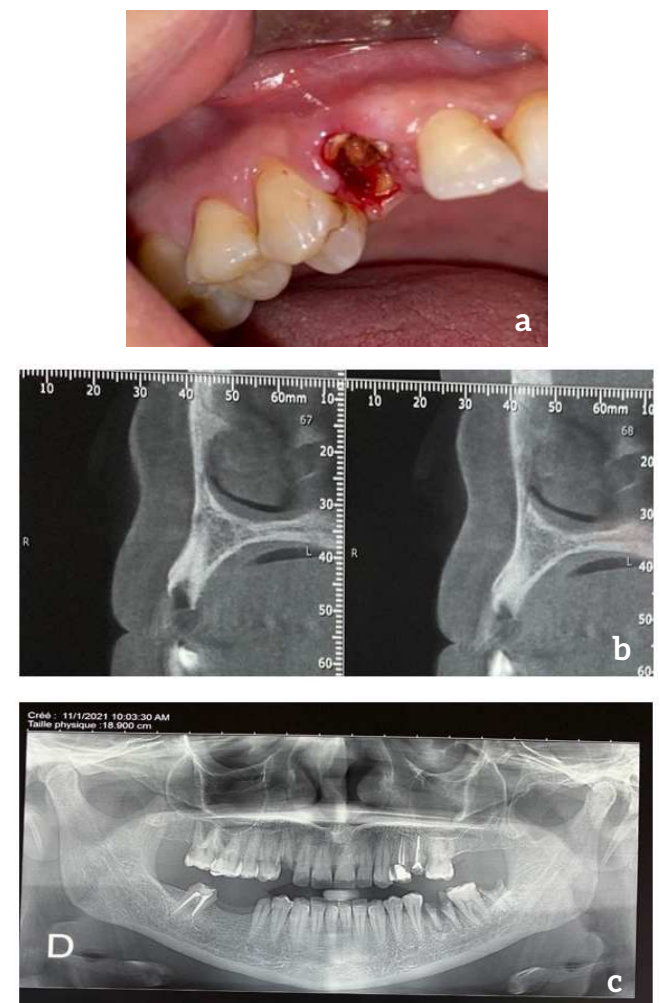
(a) Preoperative occlusal view; (b) Pre operative (CBCT); (c) Orthopantomography
